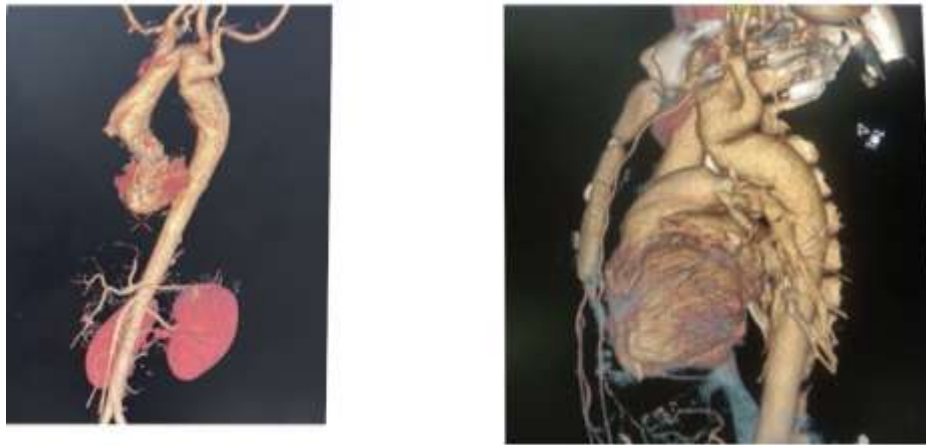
15-month-old male child with chest complaints. Volume-rendered reconstructed CT image depicting pseudo-coarctation of the aorta, characterized by elongation and folding of the aorta on itself, resulting in the appearance of coarctation.
